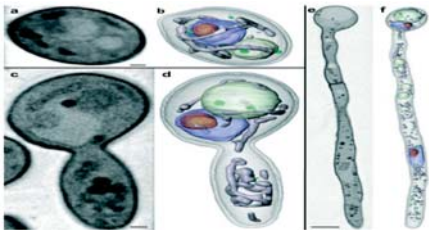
The three morphological forms of *Candida albicans* visualized in 3D by nanoscale CT. a,c and e are sections through the reconstructed tomograms. b, d and f are the same cells after the principle organelles have been segmented (Color code: nucleus in blue; nucleolus, orange; mitochondria, grey; vacuoles, white; lipid drops, green). The cell depicted in a/b is the benign form of *Candida*. c/d is a cell in transition to the pathogenic form. e/f is the fully pathogenic hyphal form. Scale bars: a,b,c, and f= 500nm; e and f = 2 microns.
